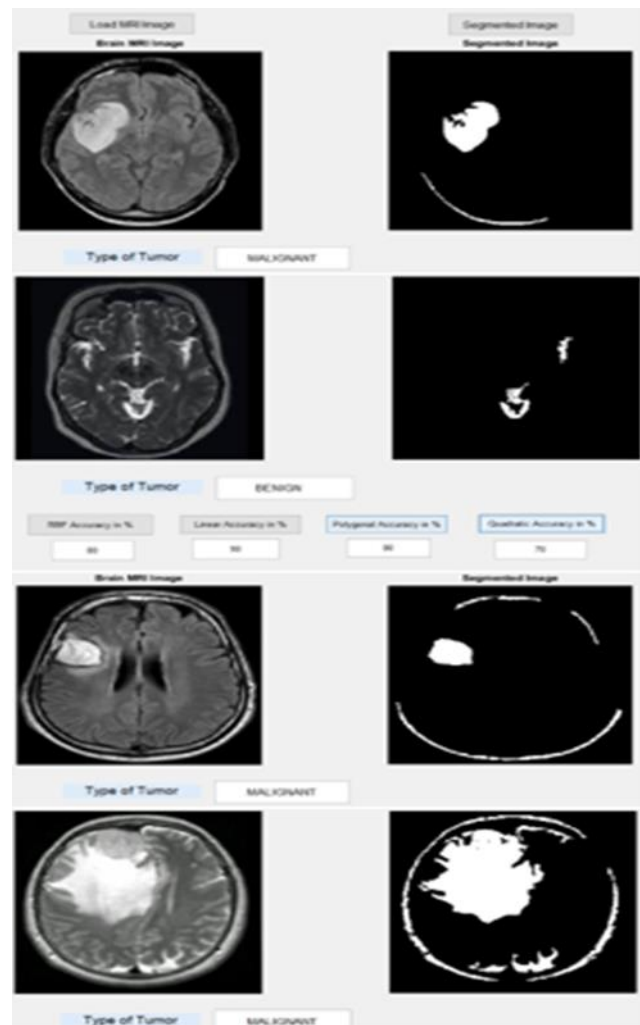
Brain MRI tumor detection and classification
